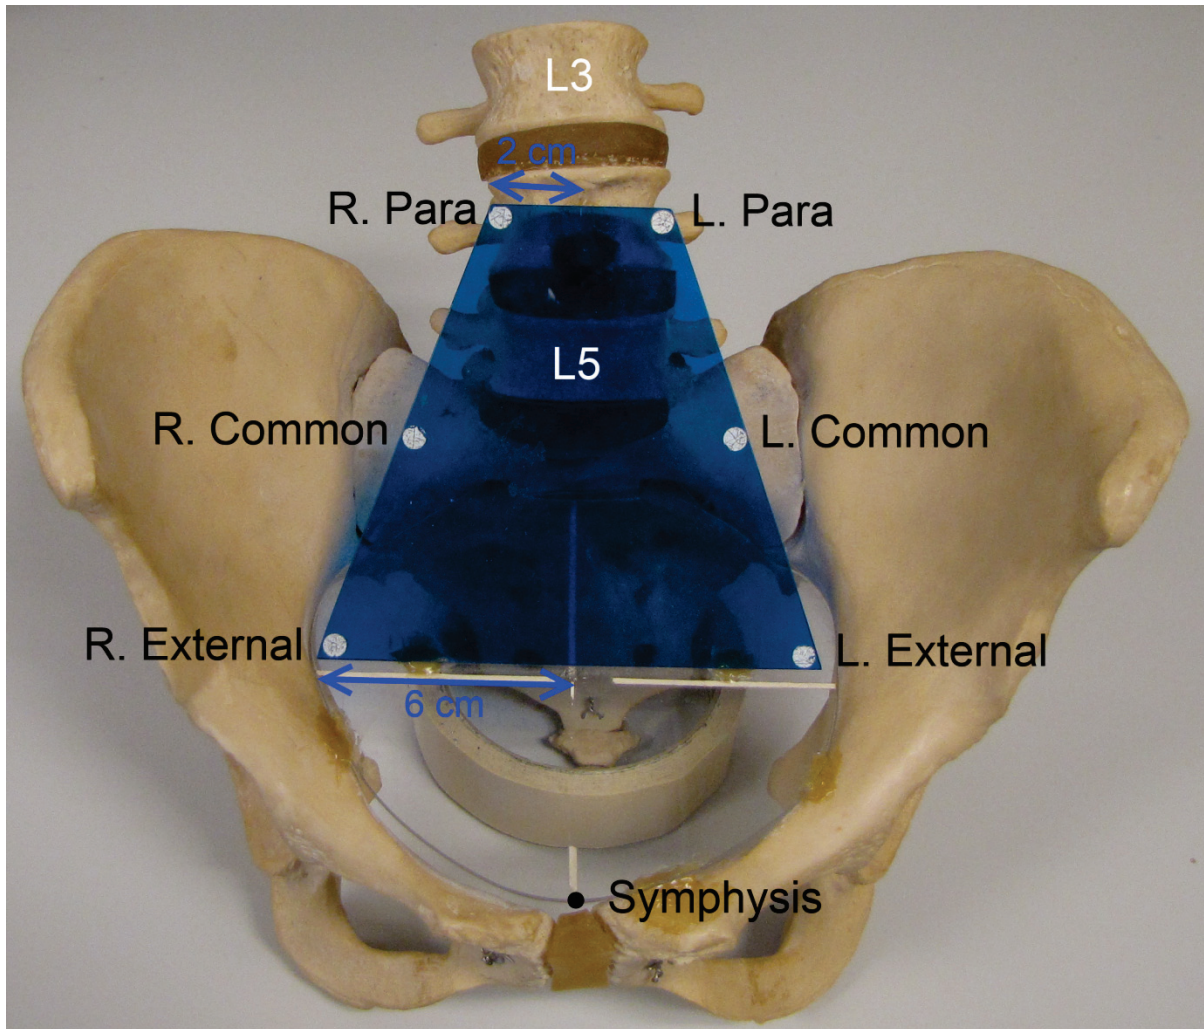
The lymphatic trapezoid of Fletcher as defined by ICRU Report 38 (61). Shows the method to determining external iliac, common iliac, and para-aortic nodal dose from x-ray films. The nodal points are based on bony locations since there is no soft tissue contrast on radiographs.
